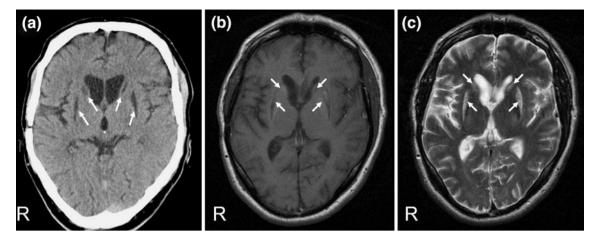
Axial computed tomography (a), T1-weighted (b) and T2-weighted (c) magnetic resonance imaging scans at the level of the basal ganglia (*arrows*). Circumscribed lesions of the caudate nucleus
